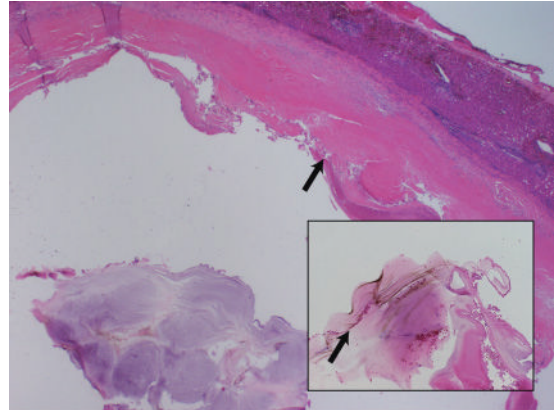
Echinococcal cyst: this 48 year old was found to have an “incidental” liver cyst on CT and ultrasonography when being evaluated for gall-bladder disease. This cyst was calcified with a thick fibrous rim. The organisms are no longer present. The unilocularity, thick fibrous rim with calcification, and layered acellular internal debris (inset) suggest the etiology. H & E, $\times 20$ and $\times 200$.
